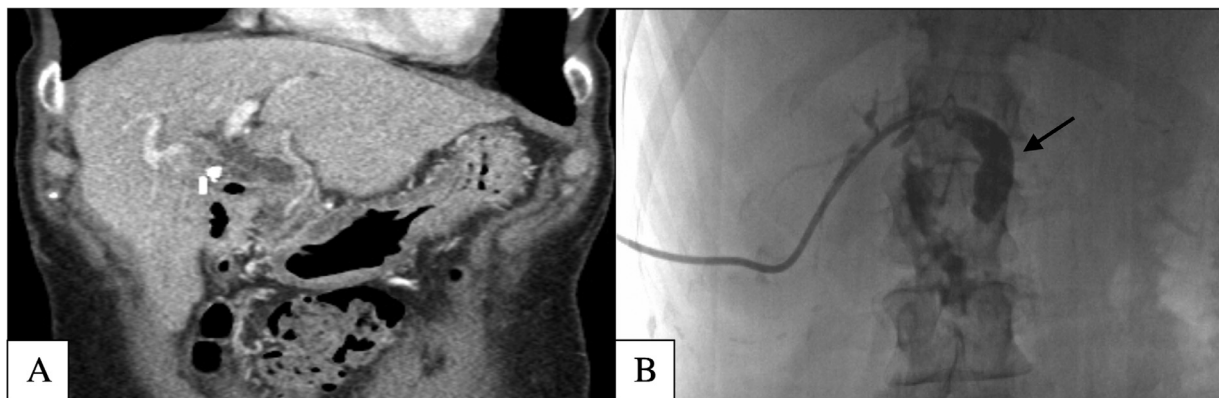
(A) Coronal view of the CT abdomen demonstrates no residual biloma. (B) Cholangiography through 10 Fr external biliary drain demonstrating no residual biliary obstruction. The common bile duct is mildly dilated but similar to appearance of baseline images prior to ablation.
